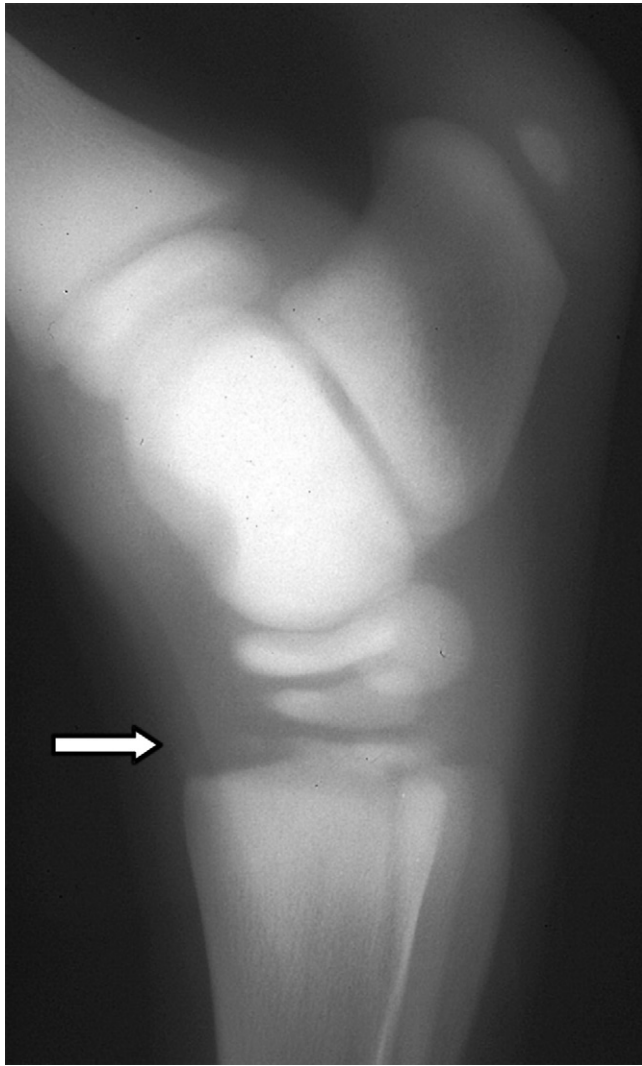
Lateromedial radiographic view of the tarsal region of 290-day-old fetus. Note the third and central tarsal bones are only rudimentarily ossified and the proximal epiphysis of MtIII (arrow) is not yet fused with the rest of the bone.
